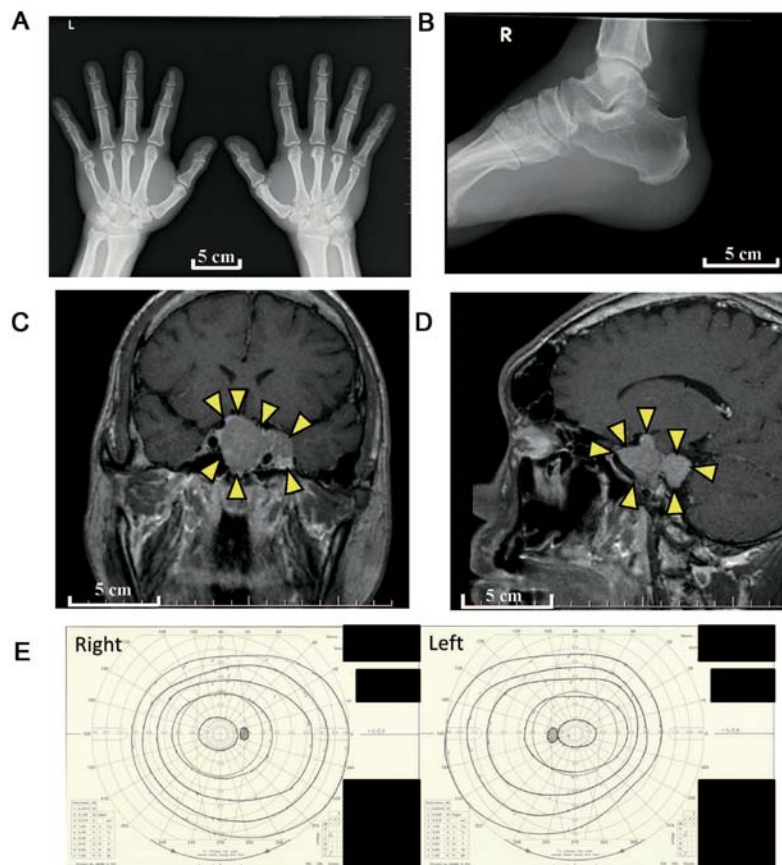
Radiographic and ophthalmic examinations. Radiographic imaging suggested (A) hypertrophied terminal phalangeal tufts and soft tissue hypertrophy, and (B) heel pad thickness. (C and D) Enhanced T1-weighted magnetic resonance imaging revealed a 4.5-cm pituitary tumor involving the left cavernous sinus. (E) Ophthalmic examinations demonstrated no vision loss secondary to the pituitary tumor.
